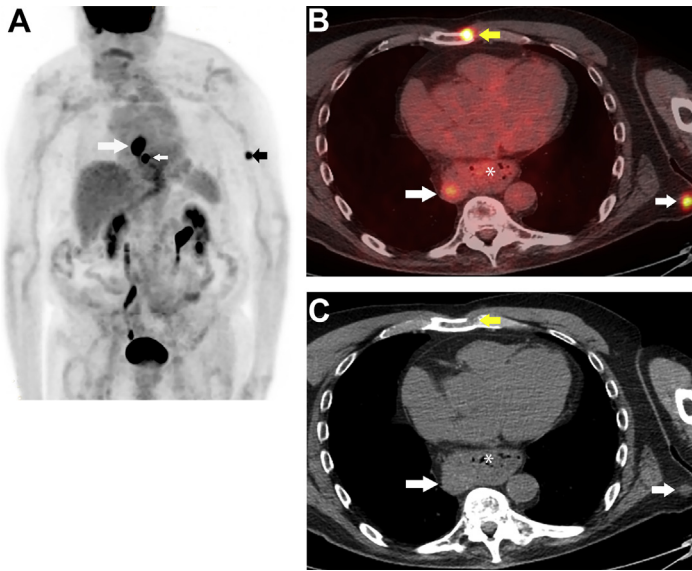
(A) Coronal WB-FDG PET demonstrates multiple regions of focal increased FDG uptake in the mediastinum (white arrows) and the left chest wall (black arrow). (B) Fused axial FDG PET/CT and (C) CT show the FDG-avid primary tumor (large arrow), lytic sternal metastasis (yellow arrow), and a soft tissue nodule in the chest wall (short arrow). Subsequent biopsy of the chest wall nodule confirmed metastatic disease. *, hiatal hernia.
